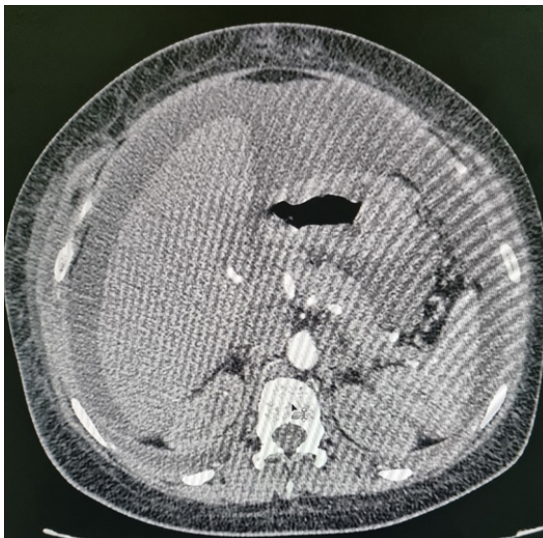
CT image showing posterior gastric thickening with abundant ascite.
